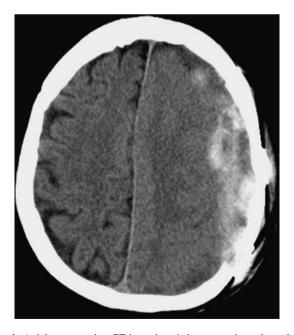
Axial preoperative CT in patient 1 demonstrating a large leftsided hematoma. Although initially read as a chronic subdural hematoma, the lesion at operation was found to be an epidural hematoma
